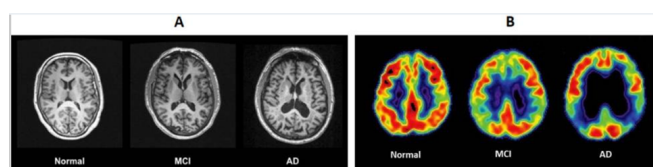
MRI scans of different progression of AD [7].
